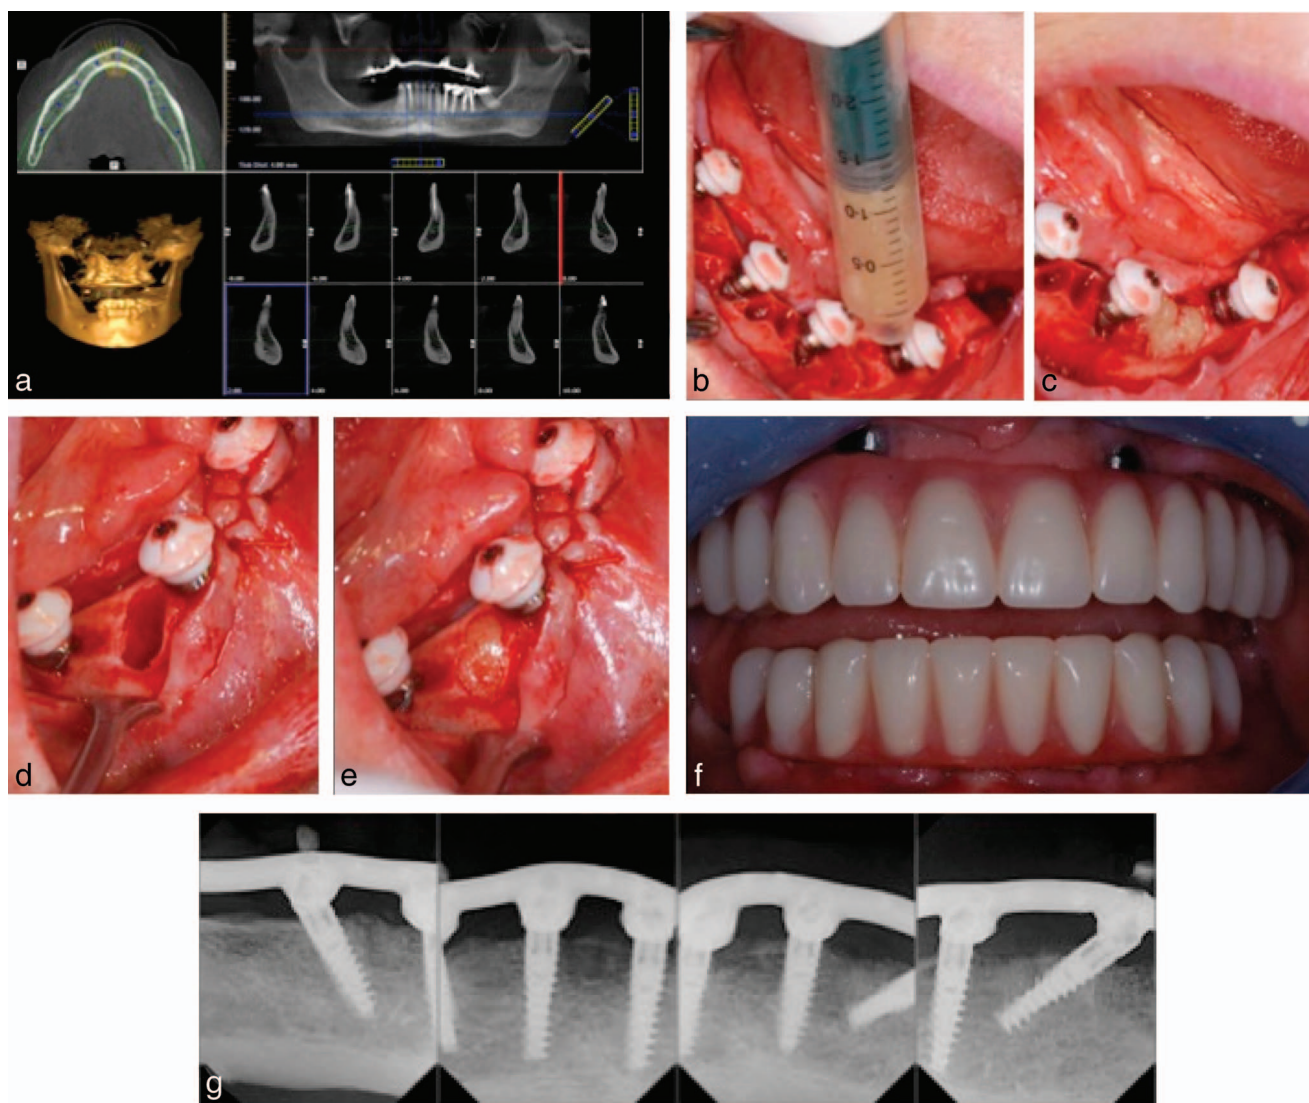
(a) Preoperative cone beam computed tomography scan. (b–d) Clinical view of postextraction sockets and all-on-four implant positions. Calcium phosphosilicate (CPS) putty graft filling extraction sockets. (c and e) Clinical view of postextraction sockets filled with CPS putty. (f) Clinical view of fixed screw-retained maxillary and mandibular definitive prosthesis. (g) Postoperative periapical radiographs demonstrating bone levels and homogenous bony profile at the 12-month follow-up appointment.
